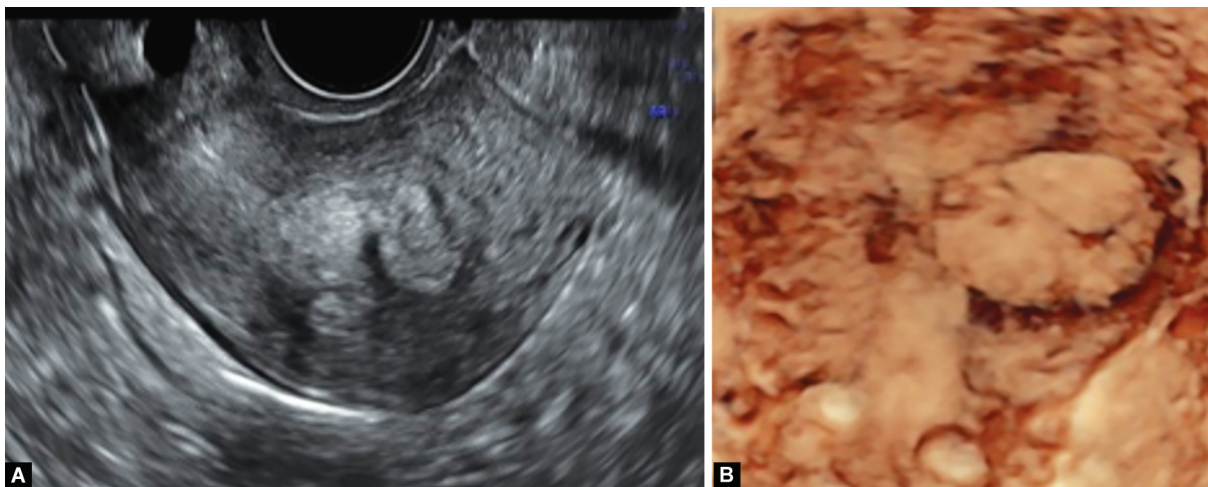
to D: 3D ultrasound: (A) The structure of adenomyosis is almost identical to fibroids, even though there is no clear demarcation; (B) Clear demarcation et leiomyoma uteri; (C) Different color Doppler network between adenomyosis (intralesional); (D) Myoma uteri (circumferential)
